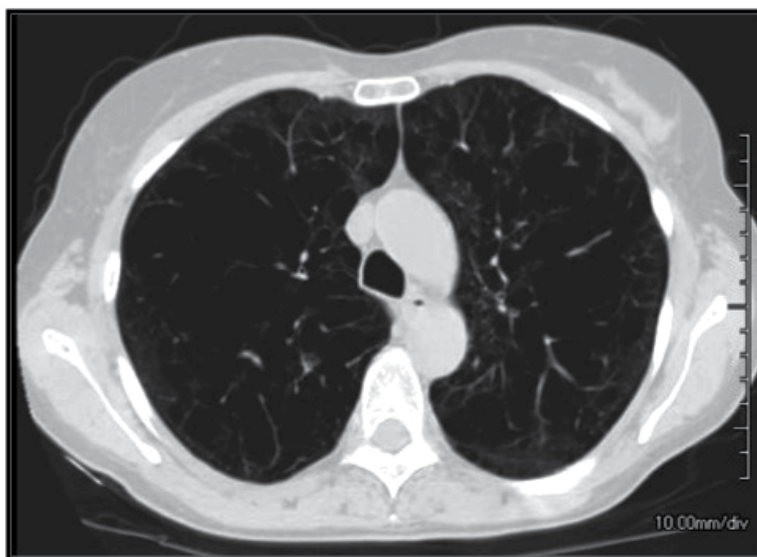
CT scan showing homogeneous destruction by emphysema in a potentially suitable candidate for the airway bypass procedure.
